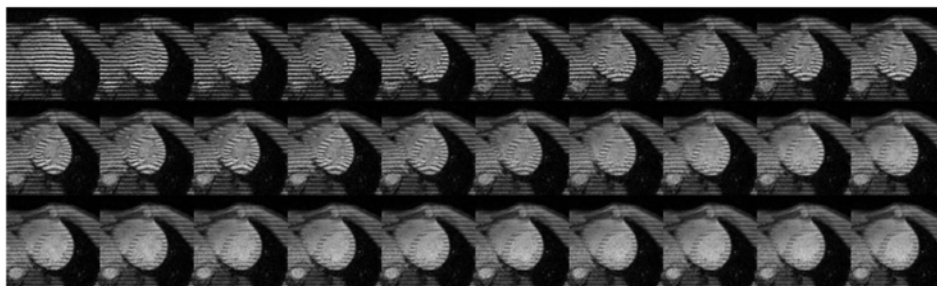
Series of 30 short-axis tagged, cinematographic MR images obtained in the same healthy heart as depicted in Figure 8.2, from the beginning of systole (top left) to end-diastole (bottom right). Images of Hans van Assen (Eindhoven University of Technology) and Jos Westenberg (Leiden University Medical Center).
